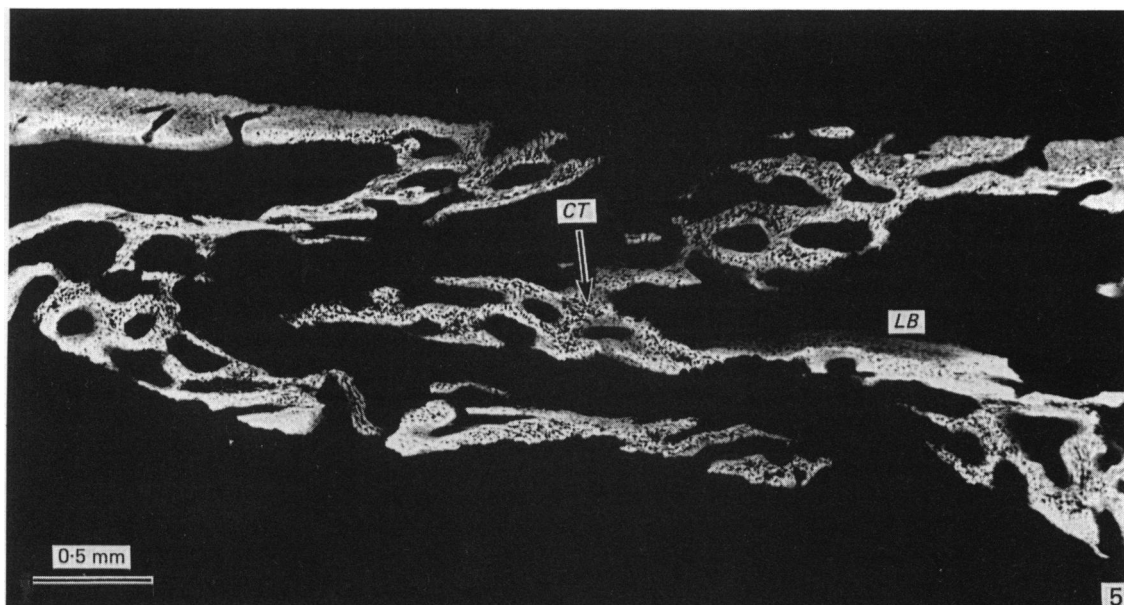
Higher magnification of the microradiograph *A* in Fig. 3. *CT*, chondroid tissue; *LB*, lamellar bone.  $\times 30$ .
